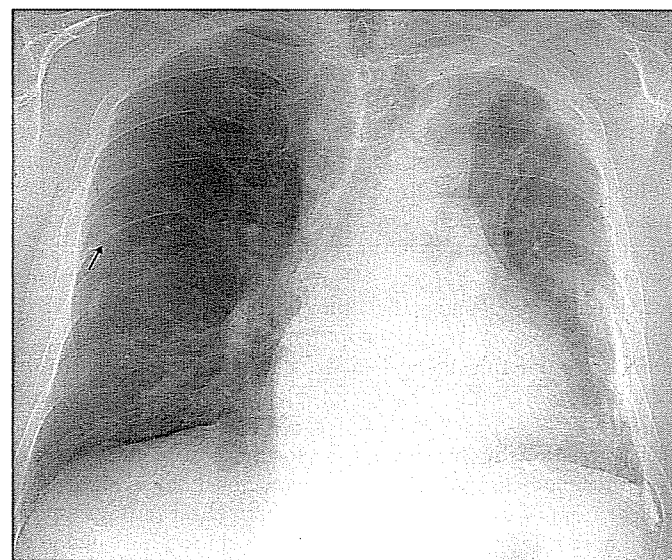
Diffuse pleural thickening. Chest radiograph shows diffuse pleural thickening around the left hemithorax, associated with calcification, and blunting of the costophrenic sulcus. A noncalcified plaque is seen en face on the right (arrow).
